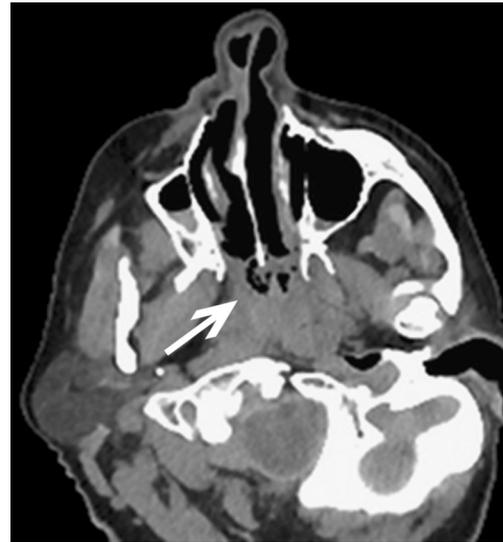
Post-mortem para-axial CT scan through the nasal cavity demonstrating frothy foam in the upper airways (*white arrows*) and also fluid in the paranasal sinuses
